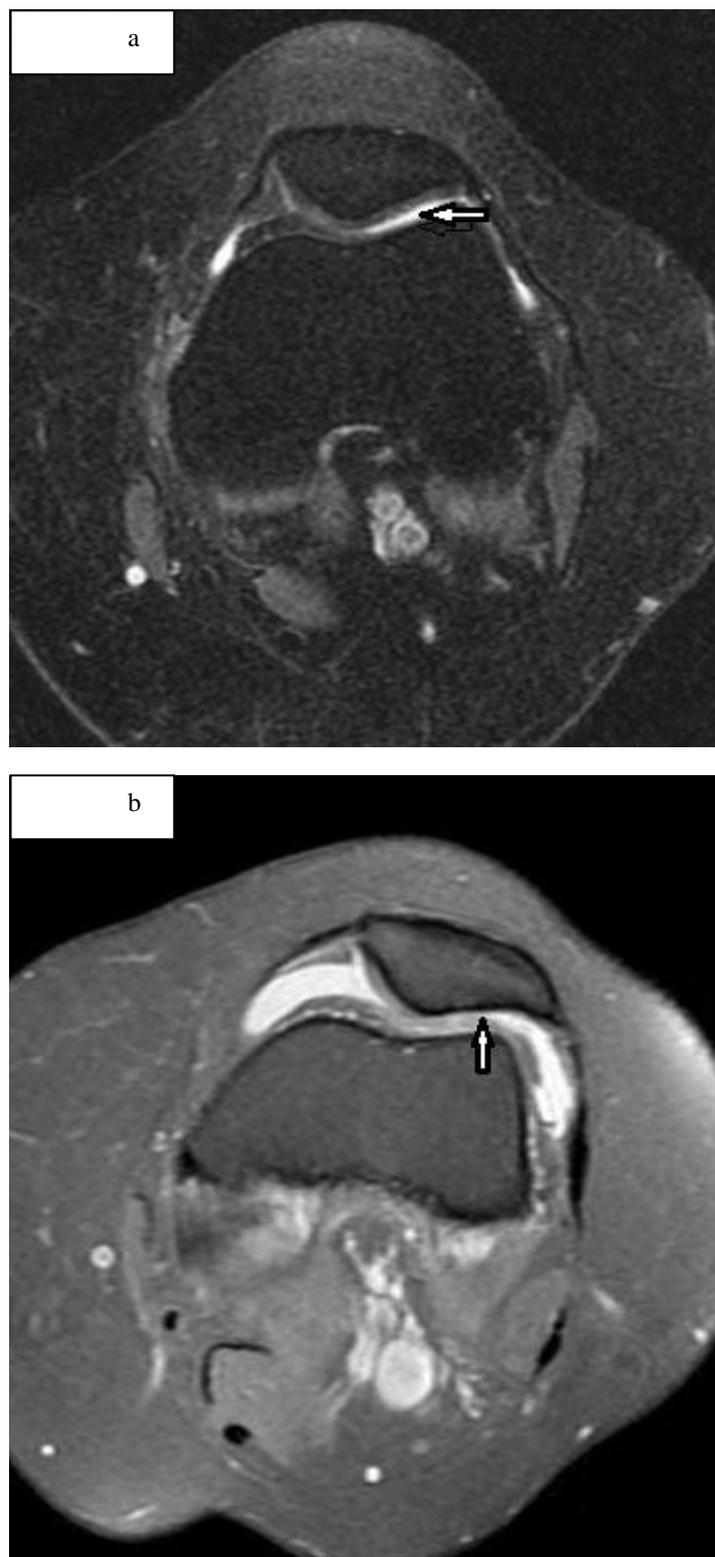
Axial fat-suppressed PDW-MR images of the knee showing (a) grade 3 and (b) grade 4 chondromalacia in the lateral facet of the patella (arrows).
